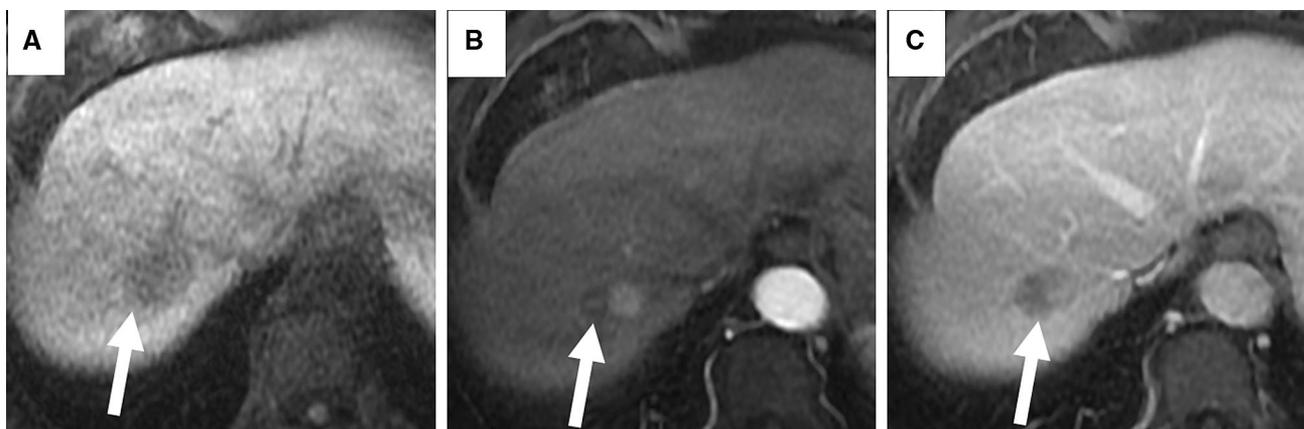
A MRI depicts a T1 hypointense lesion in segment 7 of the liver in a Hepatitis B carrier. The nodular, medial component of lesion (arrowed) demonstrated arterial enhancement (B), washout appearance (C). The lateral component of the lesion remained hypointense without
